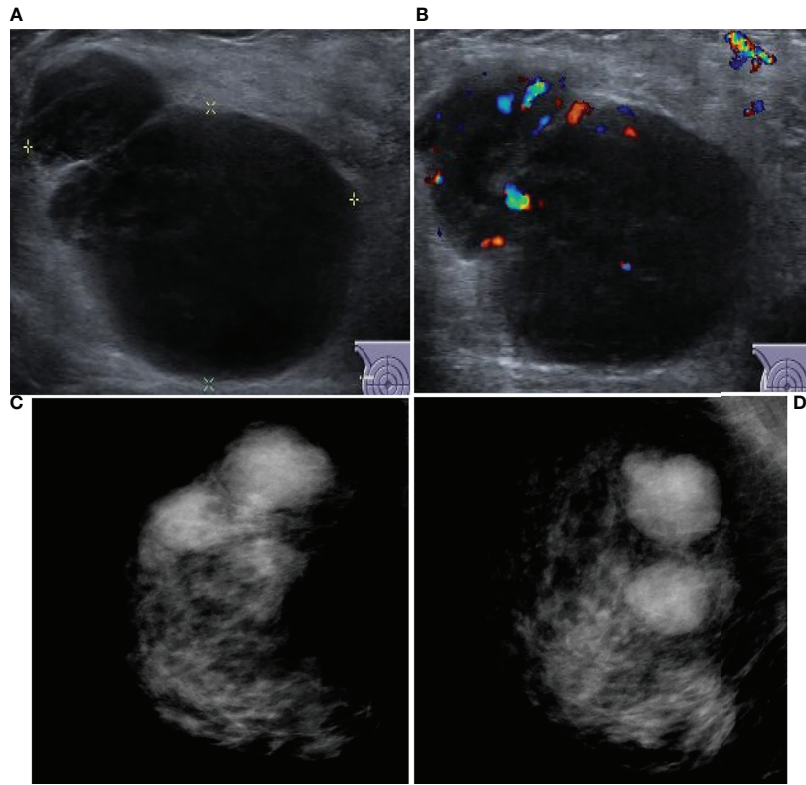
Ultrasound and mammography images for PBL. Legend: Female, 49, right non-Hodgkin breast lymphoma. (A) shows irregular hypoecho in the right breast with circumscribed margins. (B) CDF1 shows abundant blood flow signals. Right breast mammography CC position (C) and MLO position (D) image showed high density mass, no micro/macro-calcification.
